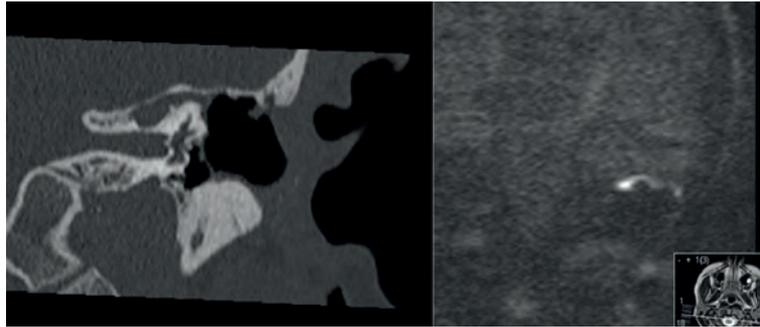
Petrous apex cholesteatoma seen on CT and diffusion weighted MRI in an only hearing ear.
